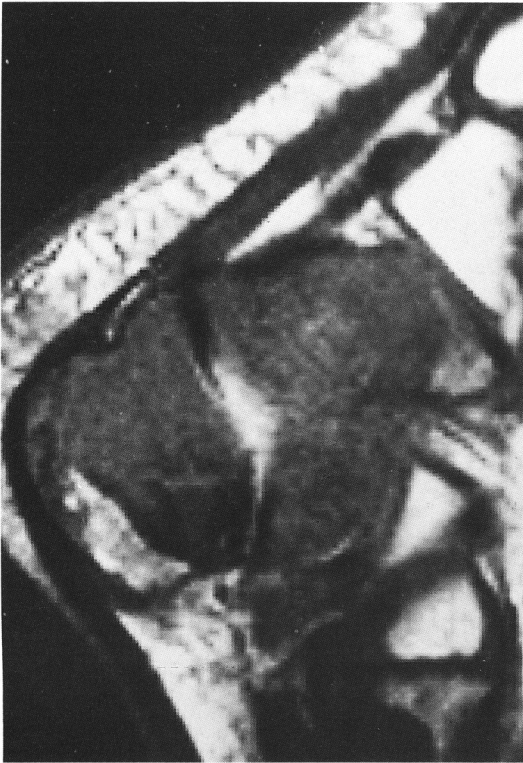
T1-weighted sagittal image of the calcaneus shows a diffusely low signal lesion with mild contour bulging of the inferior border.
